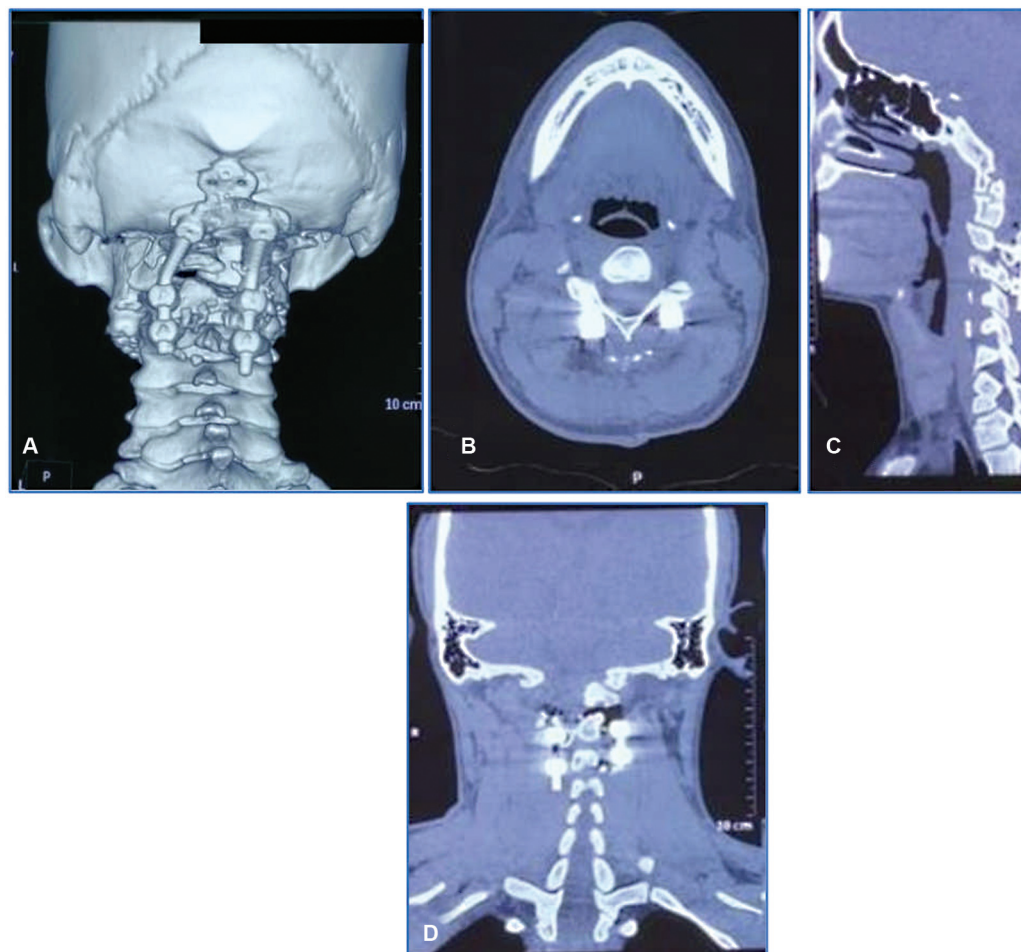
Postoperative images of computed tomography scan of craniocervical junction demonstrating (A) three-dimensional reconstruction: (B) axial, (C) sagittal, and (D) coronal section showing occipito-C2-C3 fixation with reduction in the atlantoaxial dislocation.
